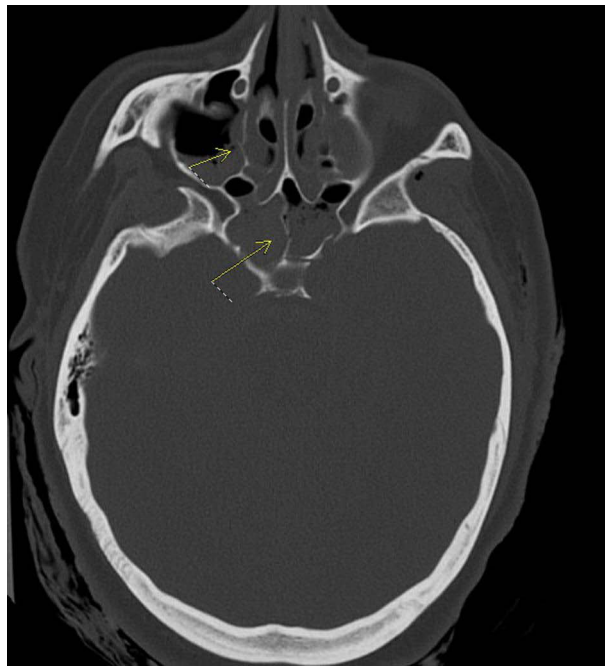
Axial view of the head CT. (Upper arrow: maxillary sinus medial wall fracture due to force of penetrating trauma) (Lower arrow: medial sphenoid septum fracture due to force of penetrating trauma).
